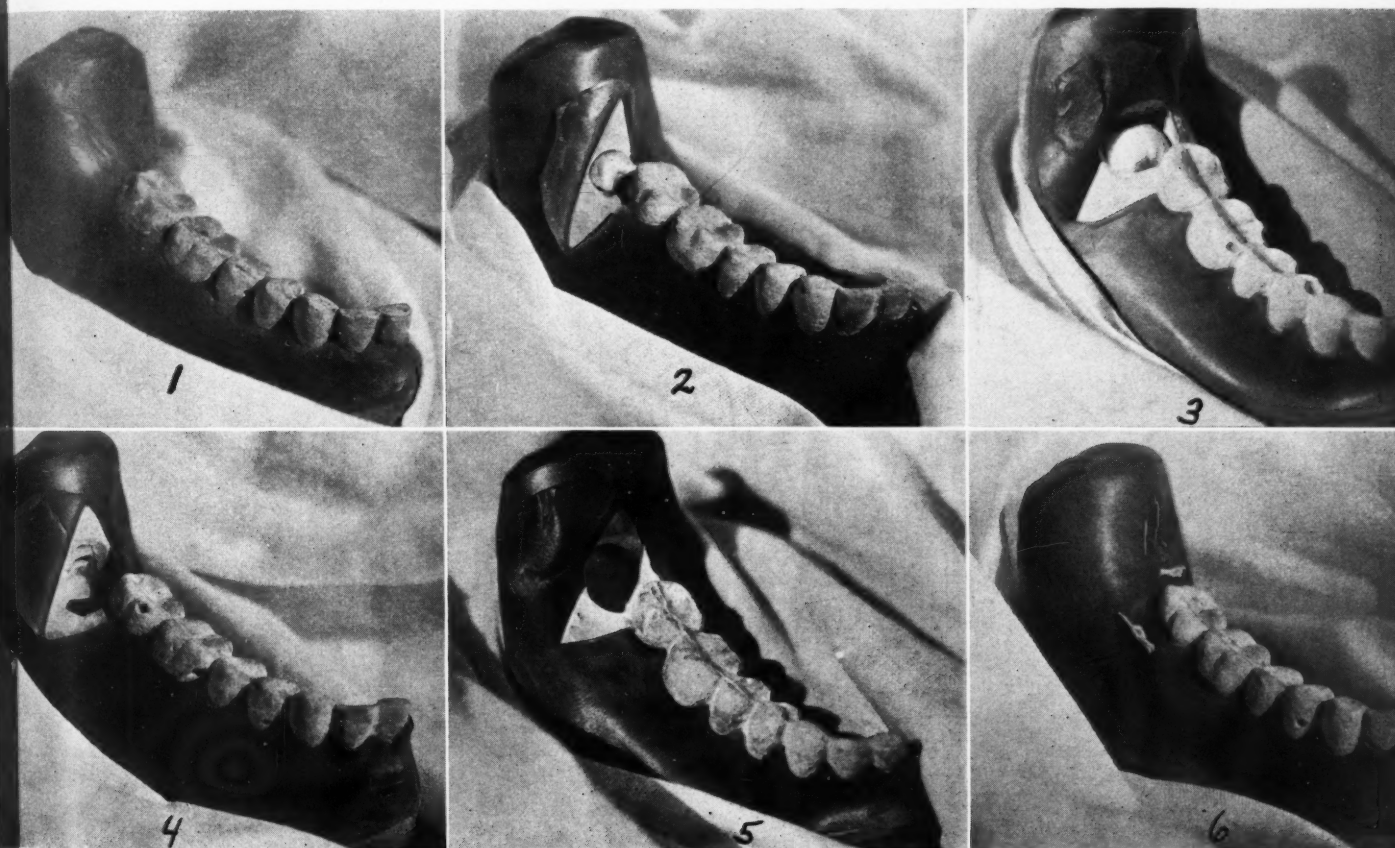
Preoperative appearance of area with impacted mandibular third molar. Lateral and occlusal roentgenograms are made before operative intervention. The anesthesia of choice is the mandibular and long buccal block. The area is isolated with gauze or cotton rolls and swabbed with antiseptic solution.
